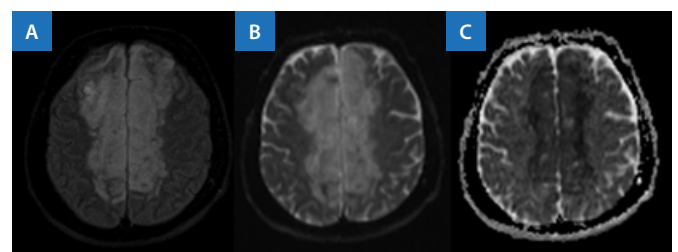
Brain MRI, axial views. Bilateral anterior cerebral artery stroke. T2*FLAIR hyperintense ischemic lesion (A). High signal on isotropic images (DWI, B) is confirmed by ADP maps (C) to represent abnormal restricted diffusion.
